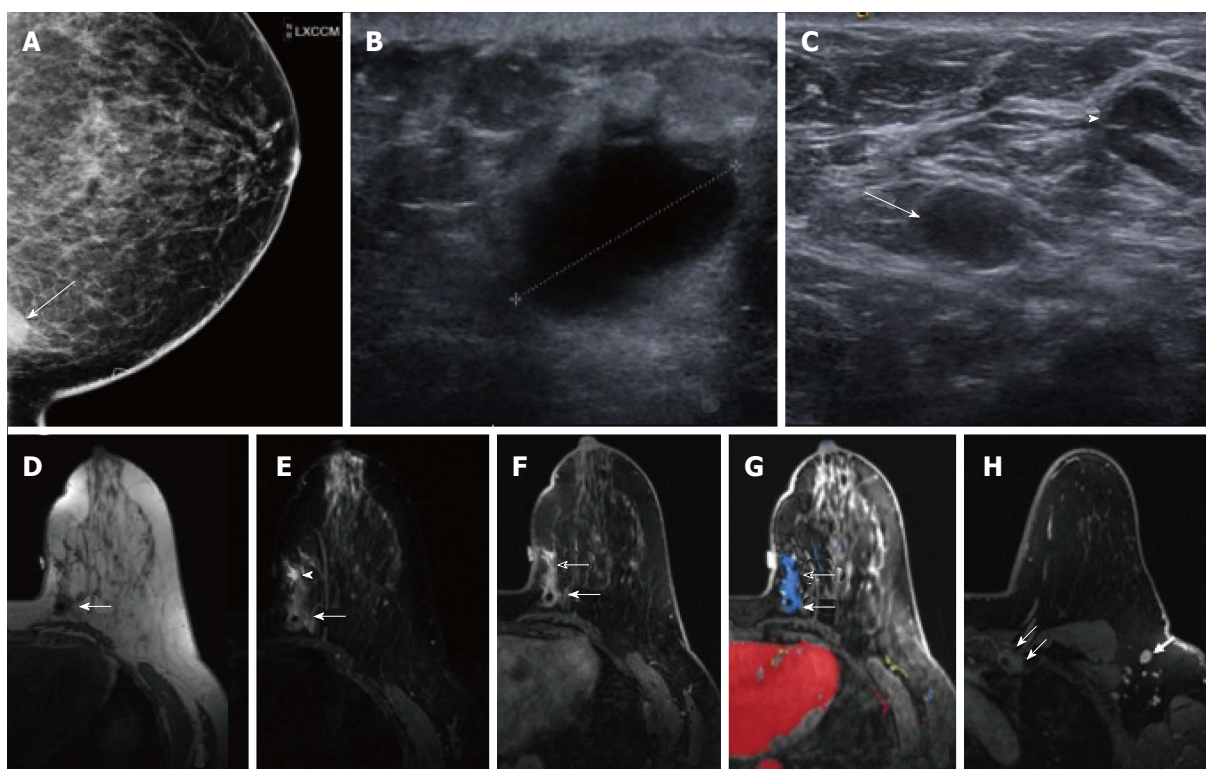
Imaging findings. A: Medially exaggerated cranio-caudal mammographic view of the left breast demonstrates the anterior aspect of the palpable mass that is a partially circumscribed and partially indistinct mass at 9 o'clock, posterior left breast (arrow); B: Ultrasound of the palpable lump demonstrates a 2.1 cm indistinct irregular hypoechoic solid mass with no posterior shadowing (caliper); C: Ultrasound of the left axilla demonstrates multiple oval and rounded lymph nodes measuring up to 1.4 cm. One oval 1.1 cm lymph node is diffusely hypoechoic (arrow) and is targeted for ultrasound guided Fine Needle Aspiration. The majority of the remaining lymph nodes demonstrate a thickened cortex (arrow head); D-H: Breast MRI: axial images of the left breast shown in multiple series as below; D: On pre-contrast T1W non-fat suppressed imaging the palpable mass is a 2 cm irregular mass with a central artifact from clip (arrow); E: On pre-contrast T2W fat suppressed imaging the mass is isointense to slightly hyperintense relative to the breast parenchyma (arrow). Similar signal is noted anterior to the mass with a higher intensity area more anteriorly (arrowhead); F: On first post-contrast fat suppressed T1W imaging the 2 cm irregular mass with a clip (arrow) is enhancing. Additional non-mass enhancement is noted anterior to the mass, measuring approximately 3 cm in the anterior-posterior plane (open arrow); G: Computerized color mapping demonstrates mostly persistent kinetic pattern of the mass and non-mass enhancement (area in blue, arrows); H: First post-contrast fat suppressed T1W imaging confirms the presence of multiple abnormal level 1 (arrow) and level 2 (not shown) axillary lymph nodes and abnormal left internal mammary chain adenopathy (double arrows).
